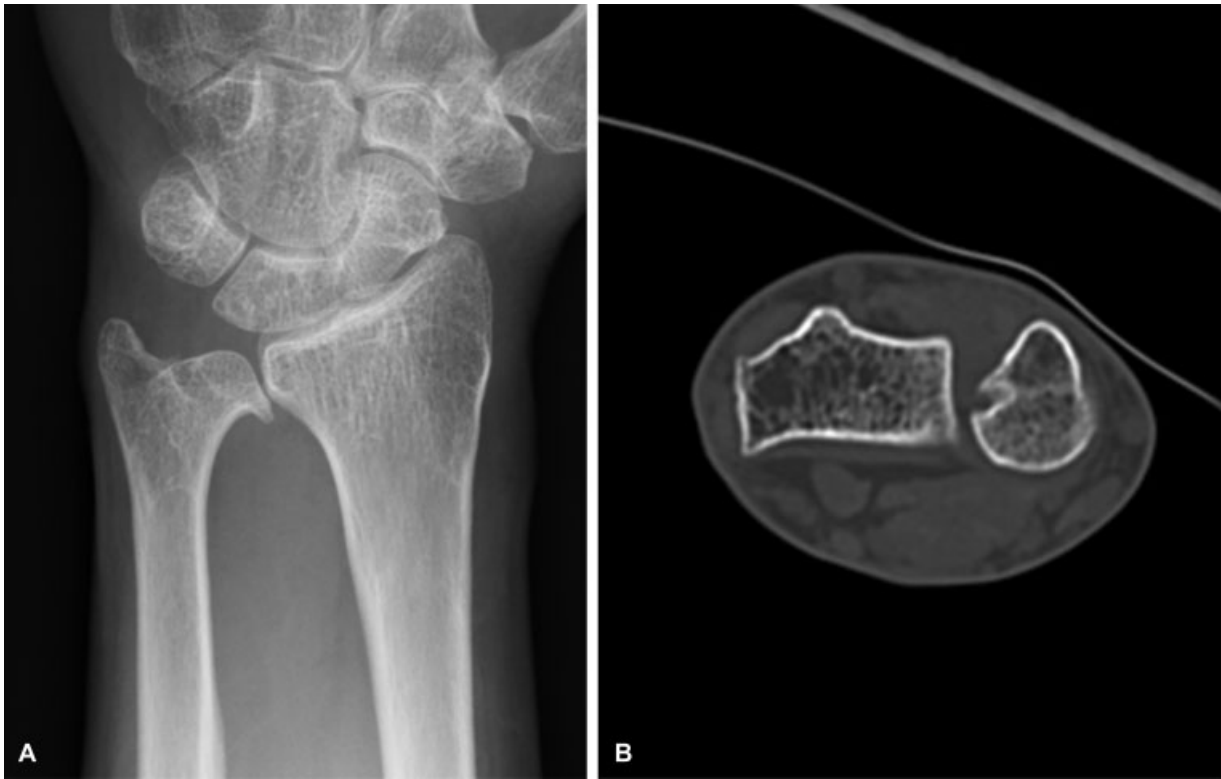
(A) Radiograph showing bone union of the ulnar head with an osteophyte 1-year post-injury. (B) Axial computed tomography view of the distal radioulnar joint in 90° of pronation. The fracture gap of the ulnar head showed a new bone gap and good articular congruency.
